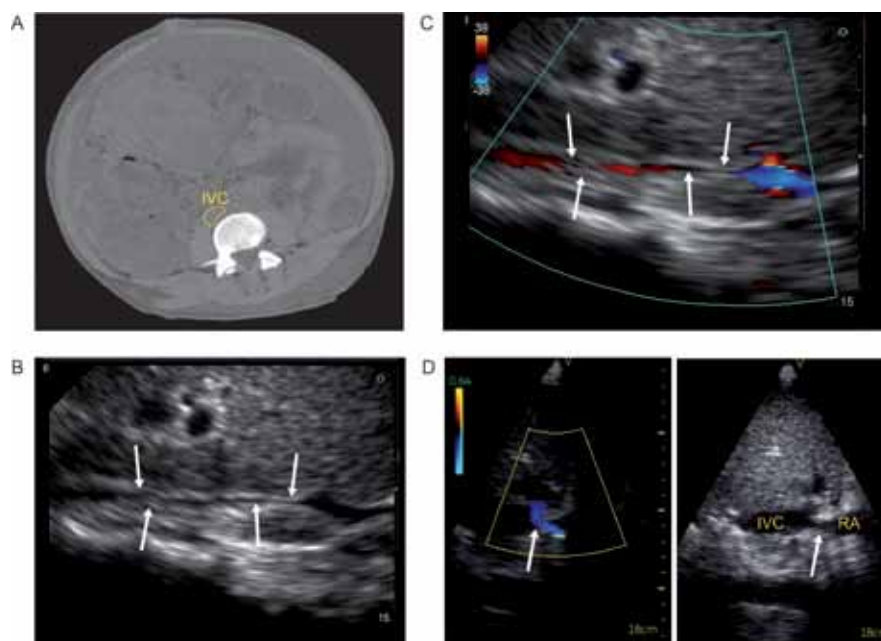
(A) Computed tomography of a patient with abdominal compartment syndrome. (B) Zoomed subphoid longitudinal view of the inferior vena cava (IVC) using bedside ultrasound shows a reduced diameter of the IVC (arrows). (C) In some patients, the compressed IVC can only be identified using colour Doppler (arrows). (D) Longitudinal subphoid view by ultrasound of a mechanical stenosis of the IVC (arrow) in a haemodynamically unstable patient after liver transplantation. Note the colour flow acceleration (arrow) at the level of the IVC stenosis.
